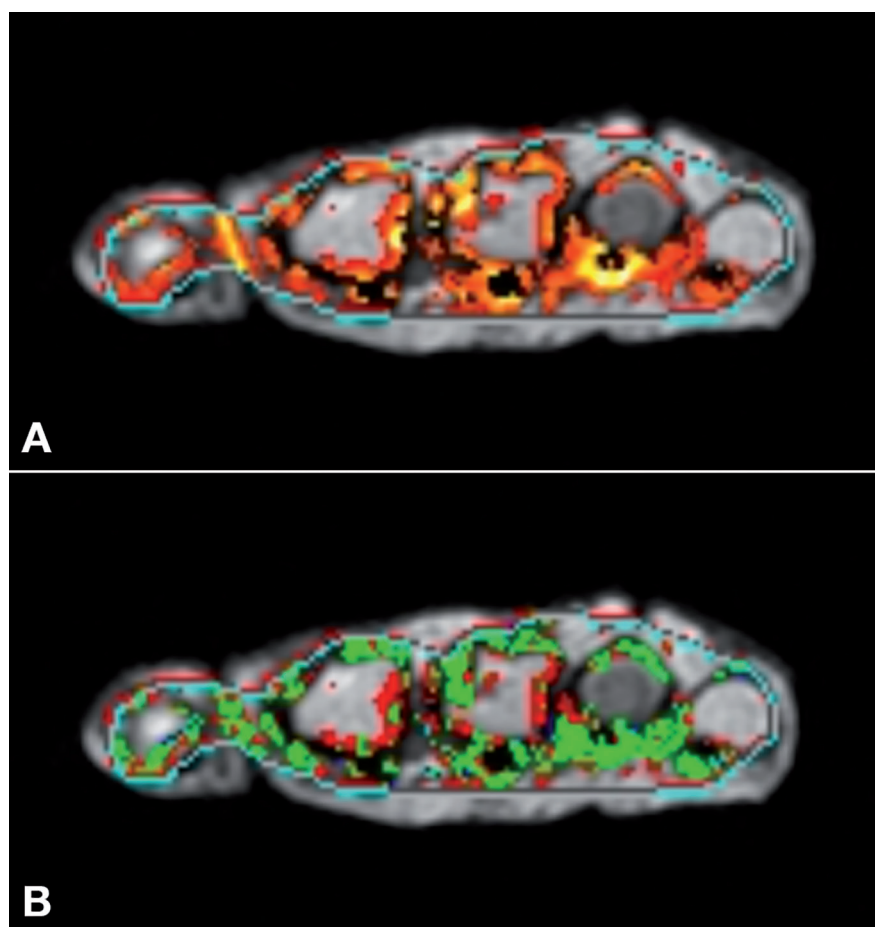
DCE-MRI of a patient with active rheumatoid arthritis. Using coloured overlay maps, various technical and physiological parameters can be visualised.
